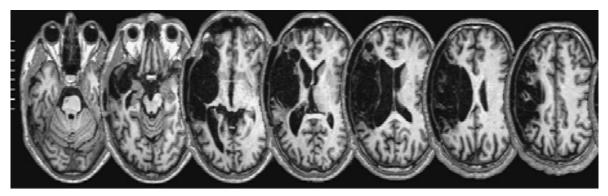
Patient's lesion and brain areas affected (axial slices, T1-weighted MRI scan, left=left)
